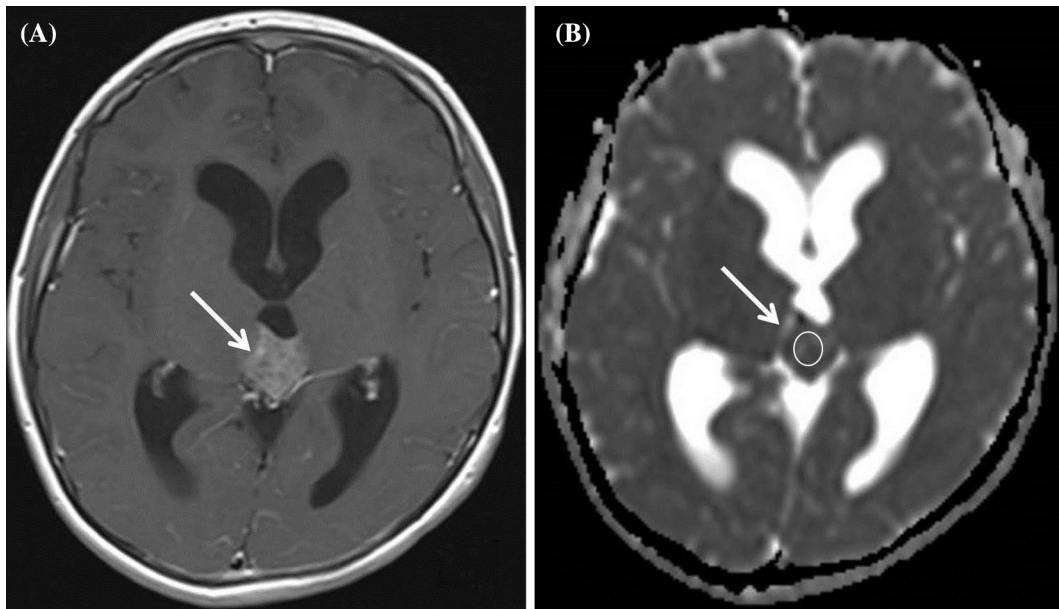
Magnetic resonance (MR) imaging from a 11-year-old boy with germinoma. Axial T1-weighted postcontrast (a) and apparent diffusion coefficient (ADC) (b) images demonstrated an enhancing
